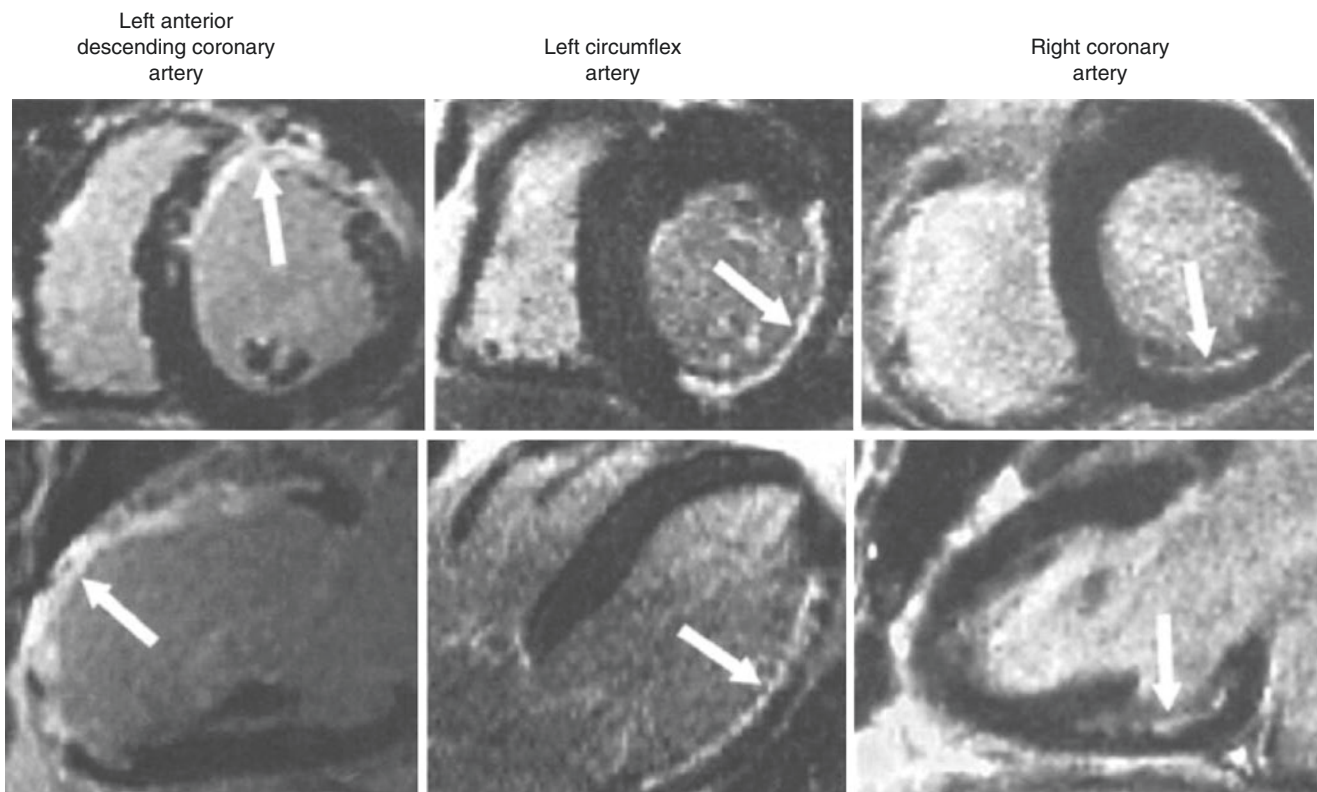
Contrast-enhanced images obtained by cardiac MRI in chronic left ventricular dysfunction. Late gadolinium-enhanced images are shown in a short-axis view (*upper panels*) and a long-axis view (*lower panels*) in three patients. Hyperenhancement (*arrows*) is present
